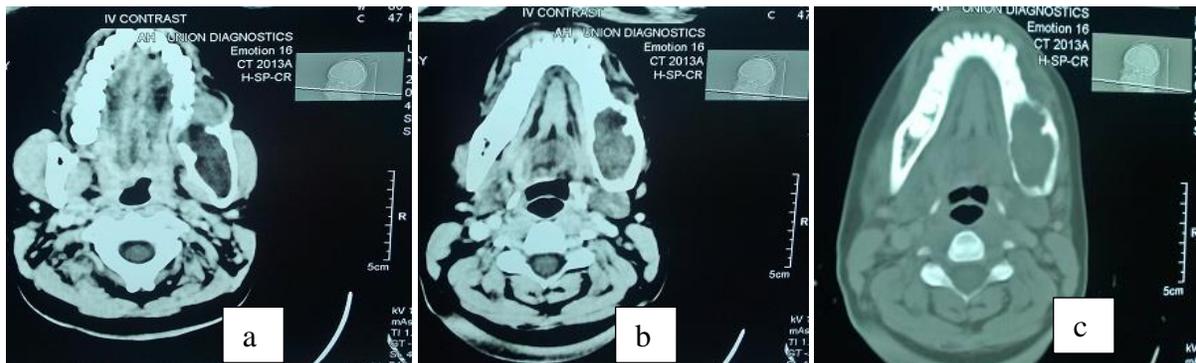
Ameloblastoma: Axial contrast enhanced computed tomographic images of soft (a and b) and bone window (c); show a large lytic soft tissue lesion of the right hemimandible with buccolingual expansion and cortical thinning. There is also cortical breach and soft tissue extension anteriorly (a and c).
